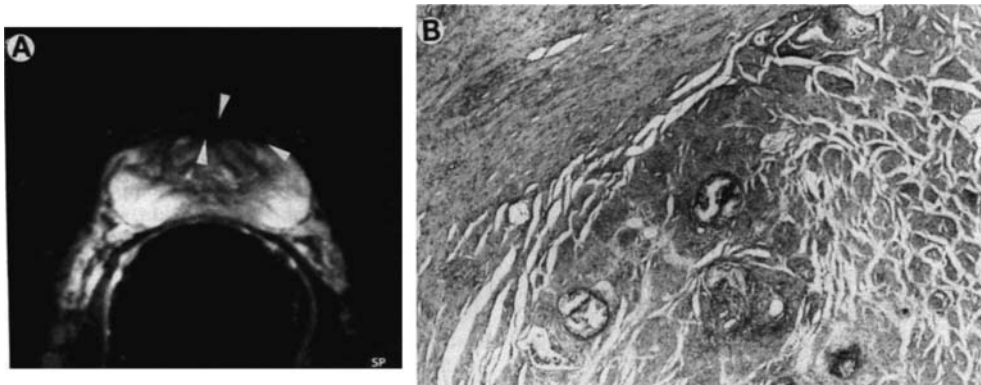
A, axial T2-weighted image shows stromal hyperplasia in anterior part of prostate (arrowheads). B, same stromal hyperplasia (upper left side). Reduced from $\times 40$.
